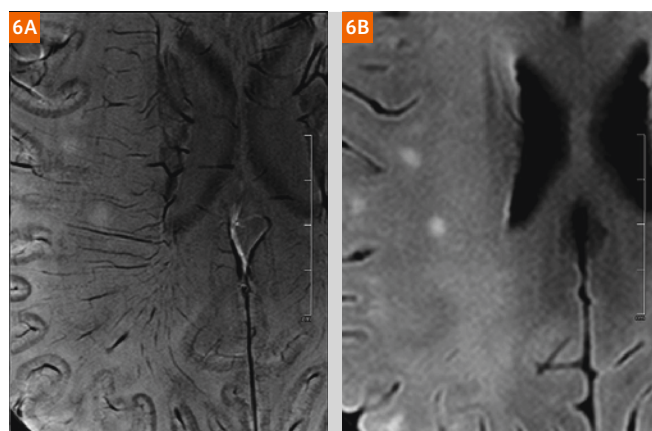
(6A) 7T axial SWI shows perivascular multiple sclerosis lesions. (6B) Corresponding FLAIR (2D TSE).
